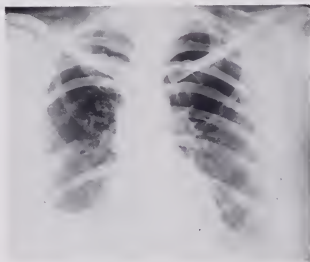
Patient M. M. Post-operative roentgenogram of the chest
